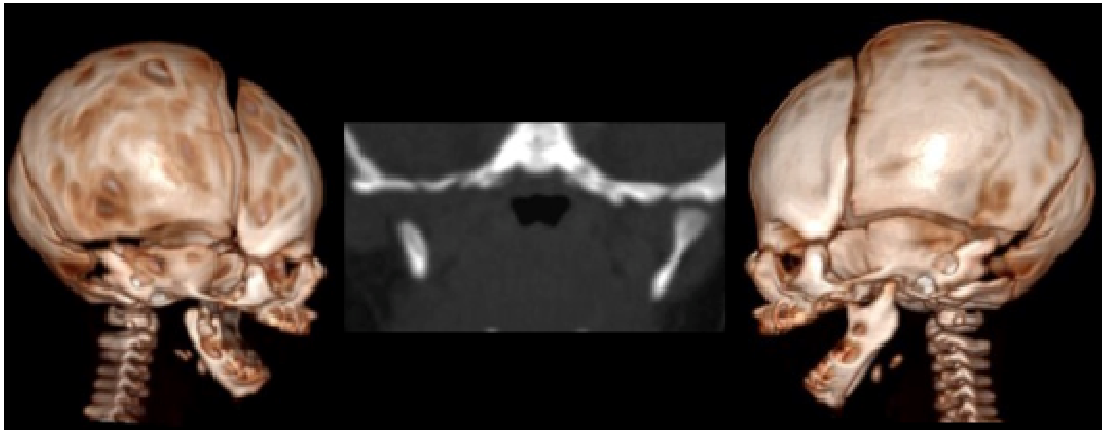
CT scan: (a-c) 3D reconstructions, (b) MPR coronal reconstruction. It's evident abnormal development of right hemimandible, with hypoplasia of the ipsilateral ascending ramus and lack of development of the corresponding mandibular condyle
